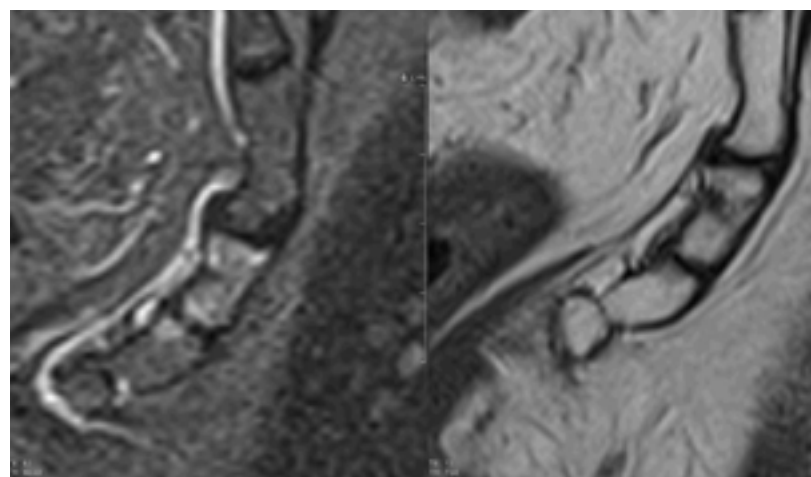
Sagittal STIR MRI on the left and T1 on the right. Recent post-traumatic context. T2 hypersignal from C1 with intraosseous discontinuity in T1, which suggests a partial fracture.
